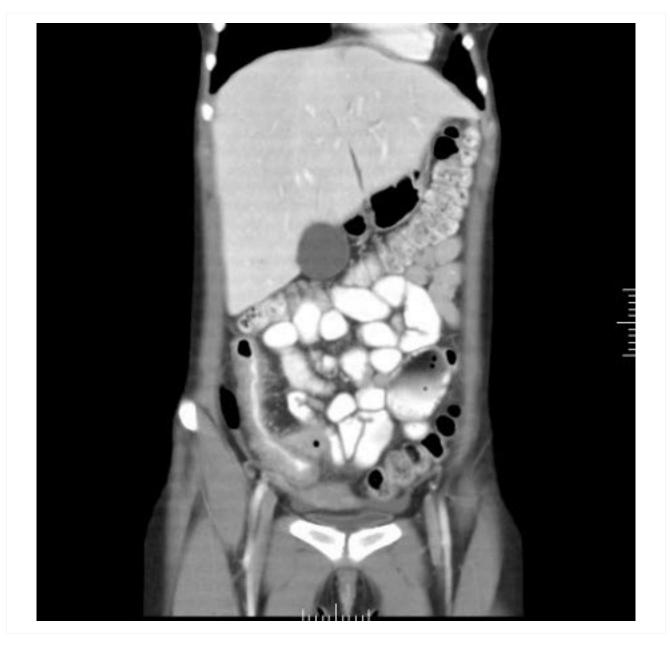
Crohn's disease: CT scan demonstrating thickening of the terminal ileum in a patient with Crohn's disease exacerbation
